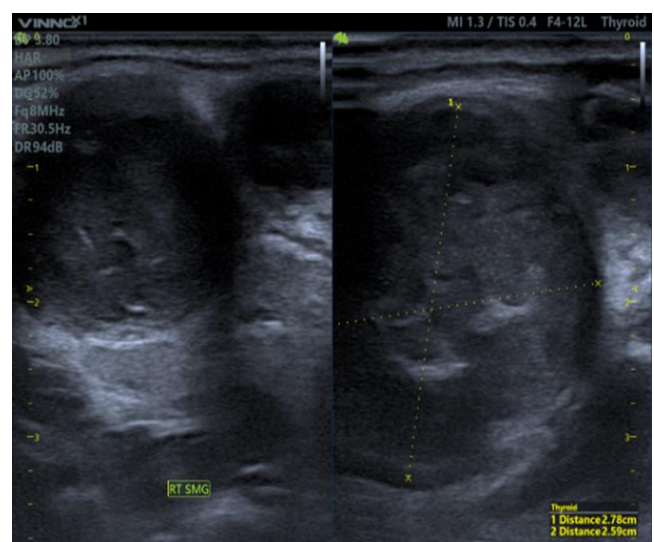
A sonogram of the right submandibular gland in longitudinal and transverse planes using a linear probe shows a well-defined heterogenous ovoid hypoechoic nodule in the right submandibular gland. It measures 2.78x2.59 cm in AP diameter.
